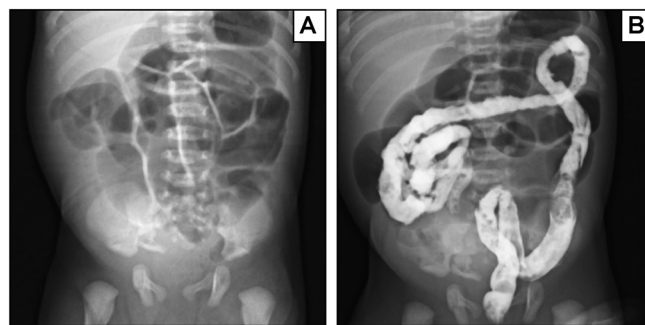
Abdominal X-ray and barium enema in isolated hypoganglionosis examinations at 11 days of birth. (A) Abdominal X-ray shows intestinal dilatation. (B) Barium enema shows microcolon due to obstruction.
